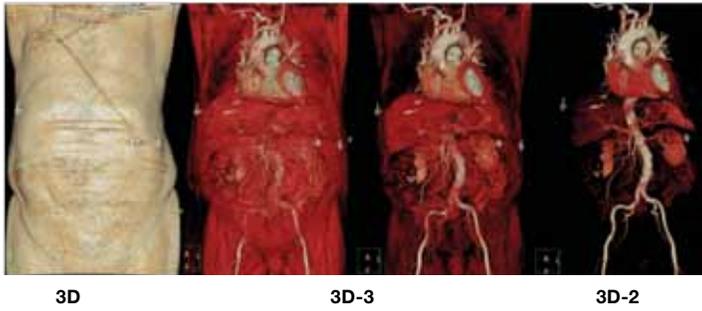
Three-dimensional (3D) volume-rendered image of aortic-iliofemoral vasculature by adjusting the CT attenuation threshold of the entire dataset (left to right) and using the bone-removal tool. The far right is a 3D volume-rendered image of the aortic-iliofemoral vasculature with bone removed. These images display the presence of significant arterial stenosis, areas of minimal luminal diameter, the presence and extent of arterial calcification and degree of vessel tortuosity. Presence of extensive calcified plaque, small arterial size, and significant tortuosity represent contraindication for transfemoral approach for TAVR.
